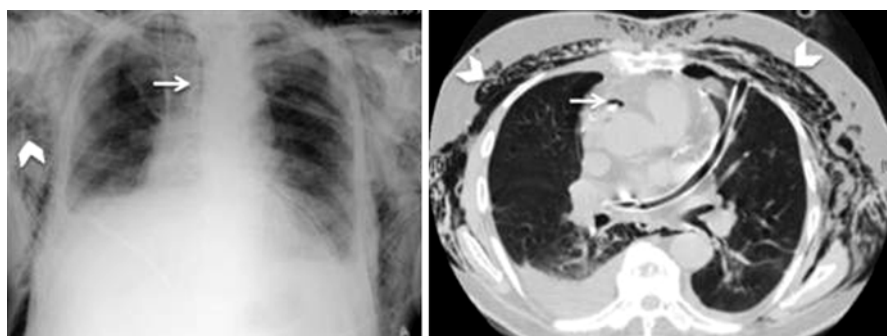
Pneumomediastinum: Chest radiograph (*left*) in a 60-year-old male following cardiac surgery shows a linear area of right paratracheal radiolucency (*white arrow*). There is also extensive bilateral subcutaneous air (*arrowhead*). CT thorax (*right, arrow*) confirms the pneumomediastinum and surgical emphysema
